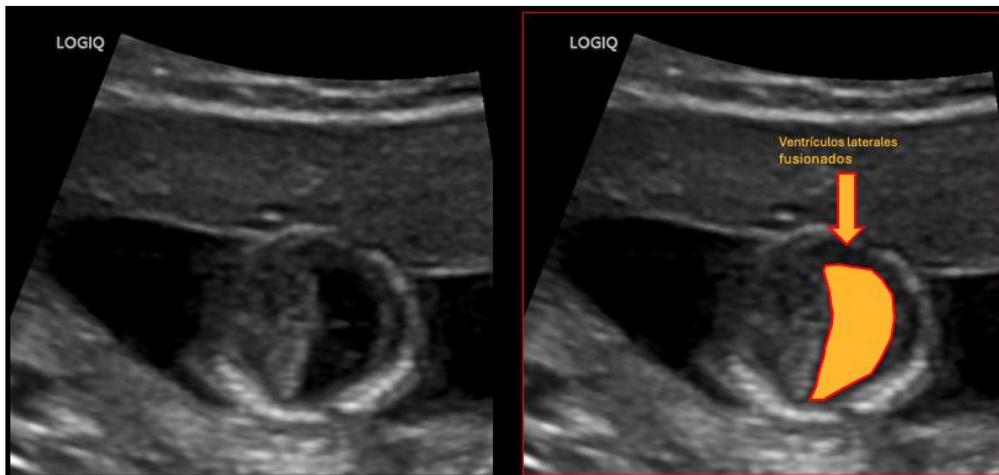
Fetal ultrasound. Axial section at the level of the cerebral thalami.
